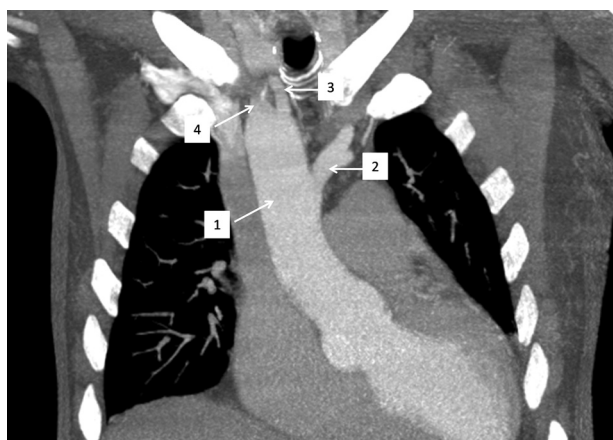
Coronal MIP reconstruction of contrast-enhanced CT image showing a right aortic arch (1) giving rise to the left brachiocephalic trunk (2), the right common carotid (3) and right subclavian arteries (4), consistent with a right-sided aortic arch with mirror-image branching.
